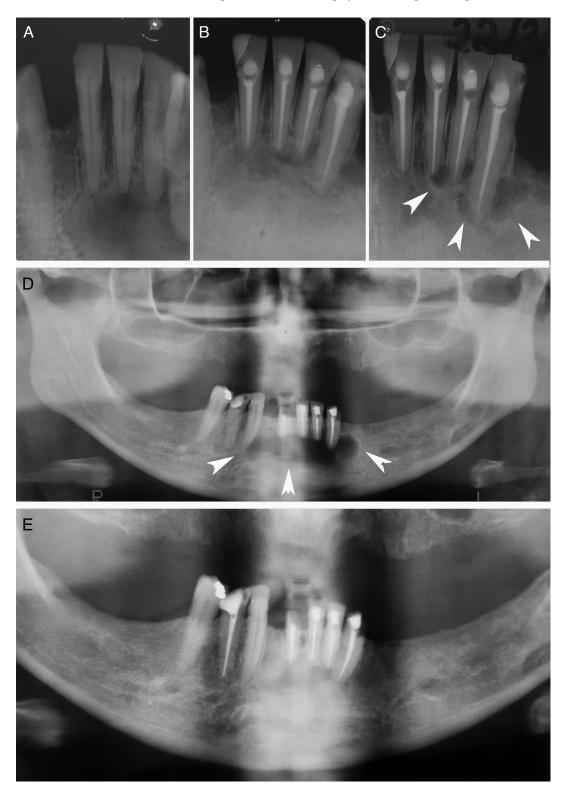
(4) A periapical radiograph showing an osteolytic radiolucent unilocular lesion in the periapical region of teeth #22, #23, #24, and #25. (B) Three months after surgical curettage, a periapical radiograph showing signs of bone repair. (C) One year later, a multilocular radiolucent lesion is associated with the root apex of teeth #22, #23, #24, and #25 (arrowbeads). (D) Two years after the previous radiographic examination, an extensive multilocular radiolucent lesion with scalloped borders is noted in the anterior mandible (arrowbeads). (E) Three months after surgical enucleation, a radiograph showing signs of bone repair.
